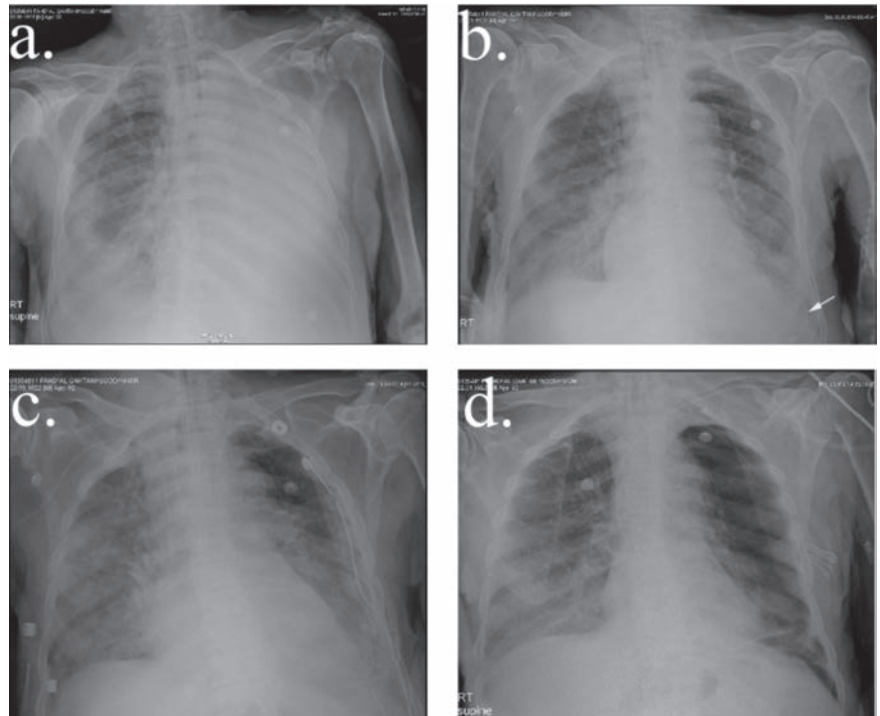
Serial chest radiographs. a) Day 24; left lung consolidation and large pleural effusion. b) Pigtail drain in left pleural space. c) Pigtail drain changed with intercostal tube because of pneumothorax. d) Post-therapy resolution of left-side pleural effusion.
